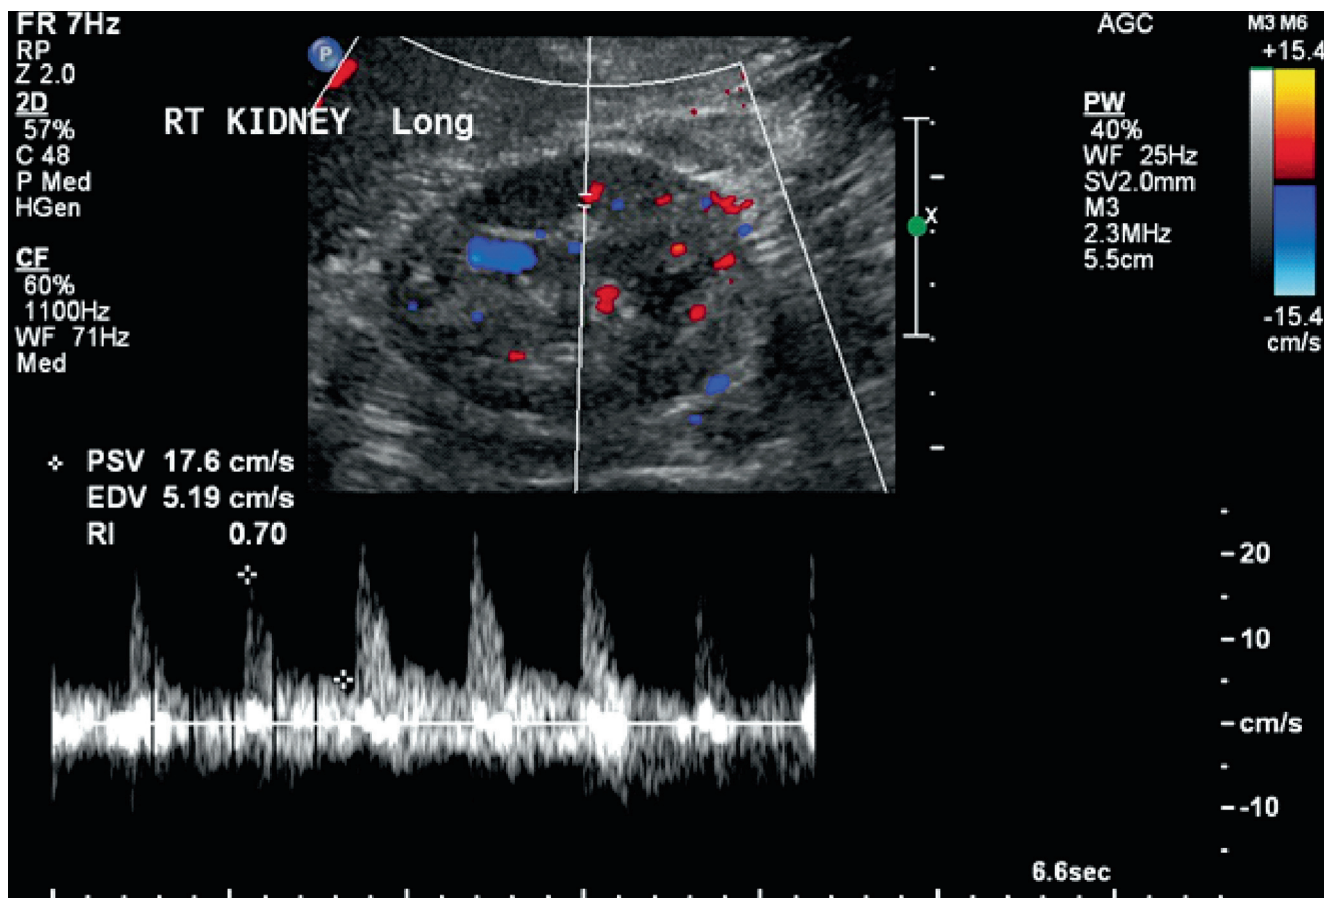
View of the right kidney using pulse wave Doppler. Note the waveform with peak systolic velocity (*PSV*) and end diastolic velocity (*EDV*) indicated. The resistive index (*RI*) is calculated as $(PSV - EDV) /$
